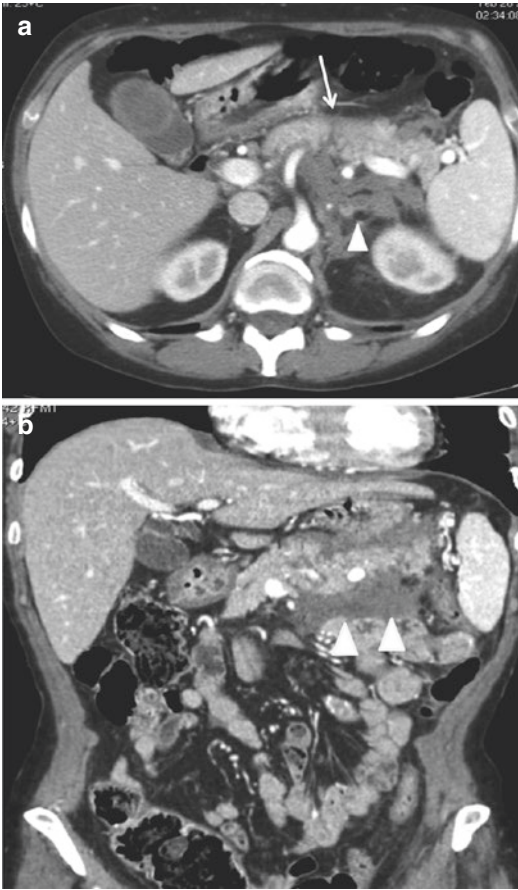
Pancreatic laceration: (a) axial CT scan and (b) coronal reconstruction show partial thickness tear of the body (*arrow*); there is a fluid collection behind and below the pancreatic body (*arrowheads*)
